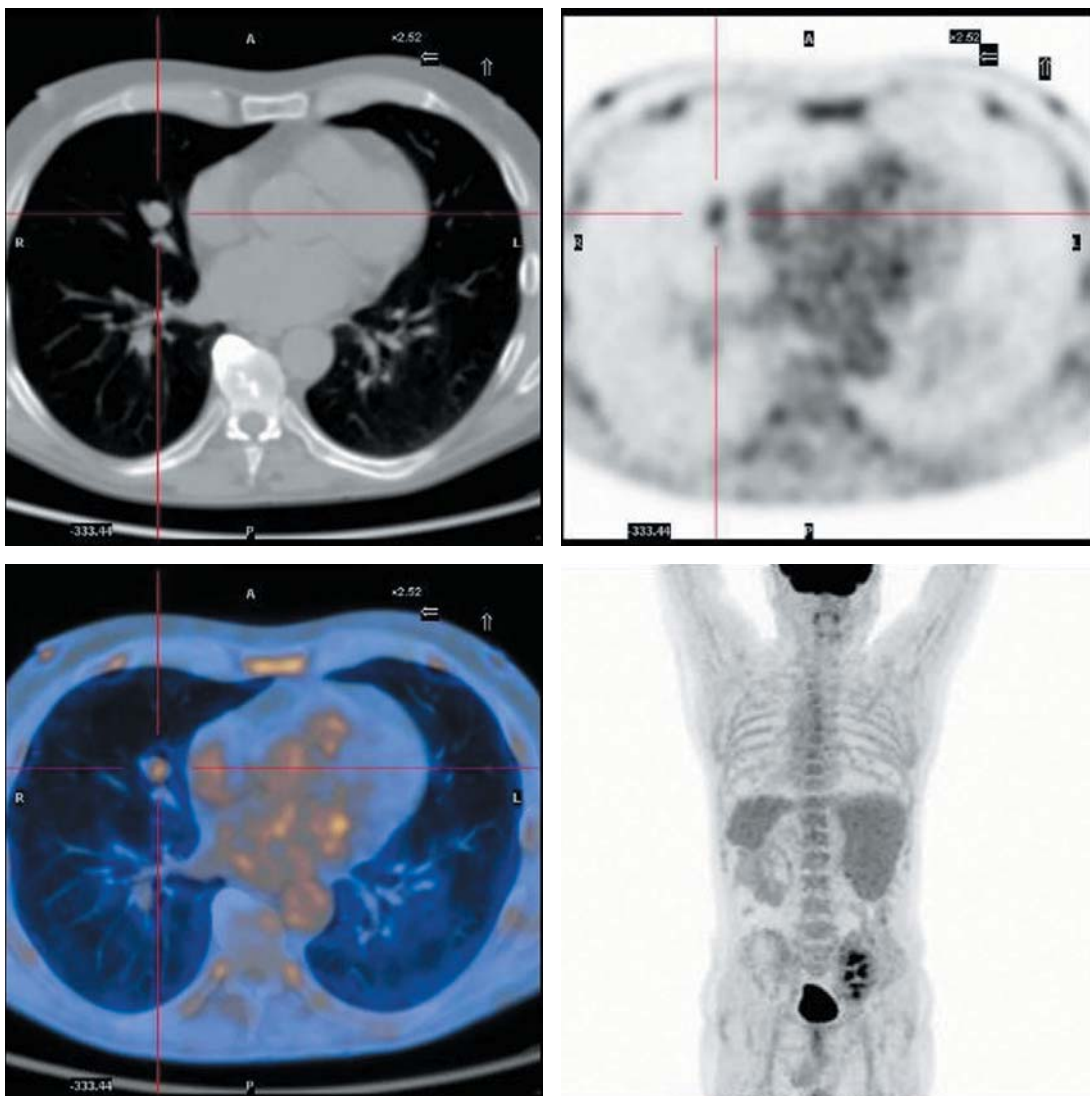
PET 18 F-FDG showing the contrast uptake of the nodule
